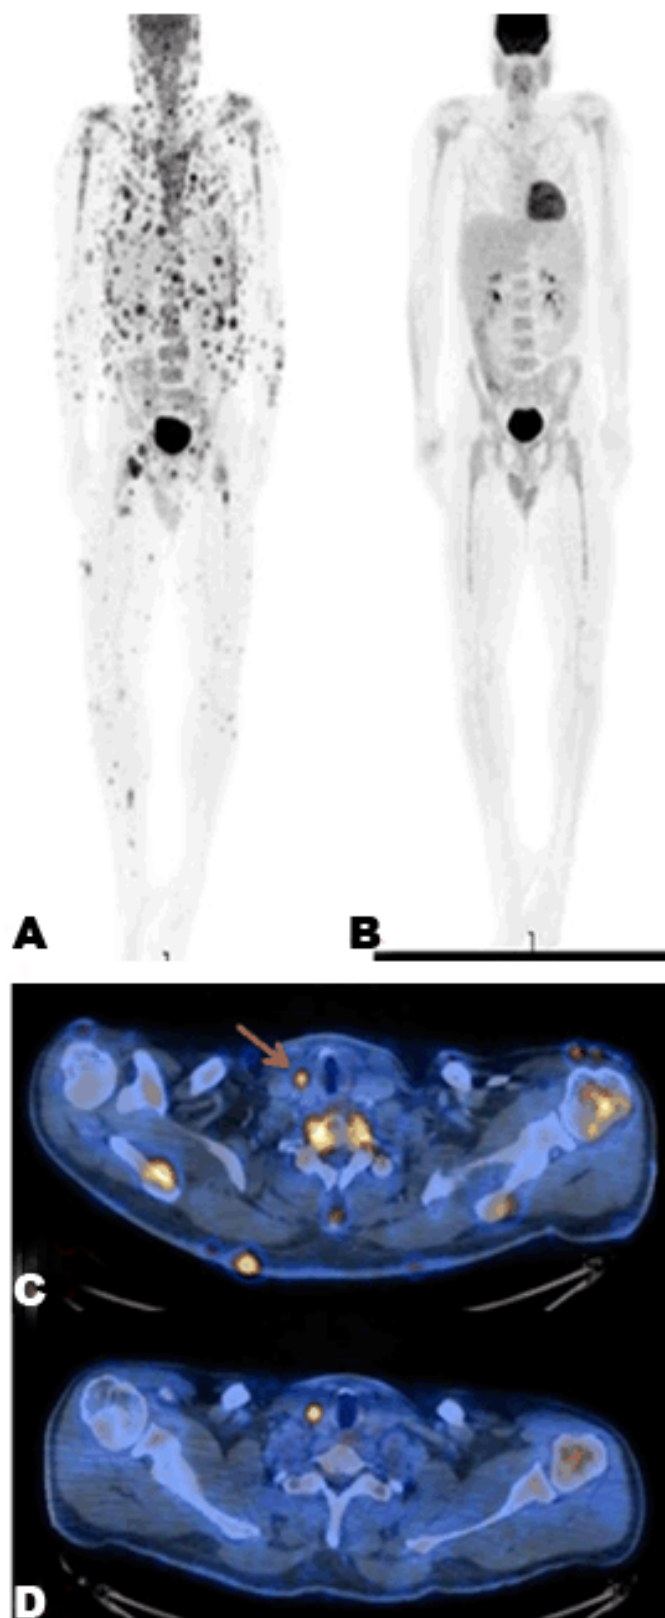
FDG-PET/CT scan at staging and following treatment of ALCL. (A) Maximal intensity projection showing disseminated skin involvement and additional nodal and extranodal sites (B), and resolution of all disease sites following treatment. (C) Axial fused images at the level of the neck show a focus pathological uptake in the staging study (arrow) and (D) following treatment that proved be PTC.
